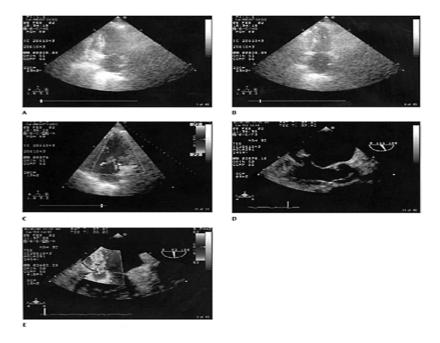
Papillary muscle rupture in a 72-year-old woman who developed cardiogenic shock 3 days after acute inferior myocardial infarction. (A and B) Transthoracic apical two-chamber views at end diastole and end systole, respectively, show normal LV size and excellent systolic function. (C) Color Doppler
